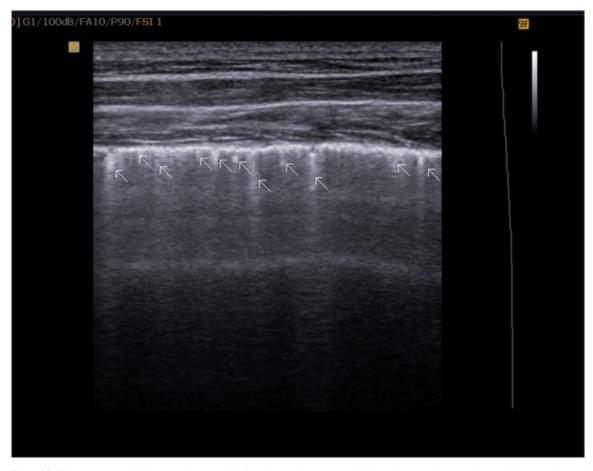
Ultrasonographic image shows multiple echogenic comet tail singe (arrows) in a patient with parenchymal lung involvement in systemic sclerosis.
